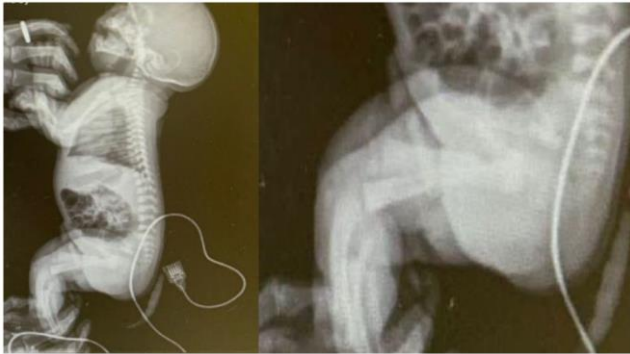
X-ray control in lateral view at 9 days.
